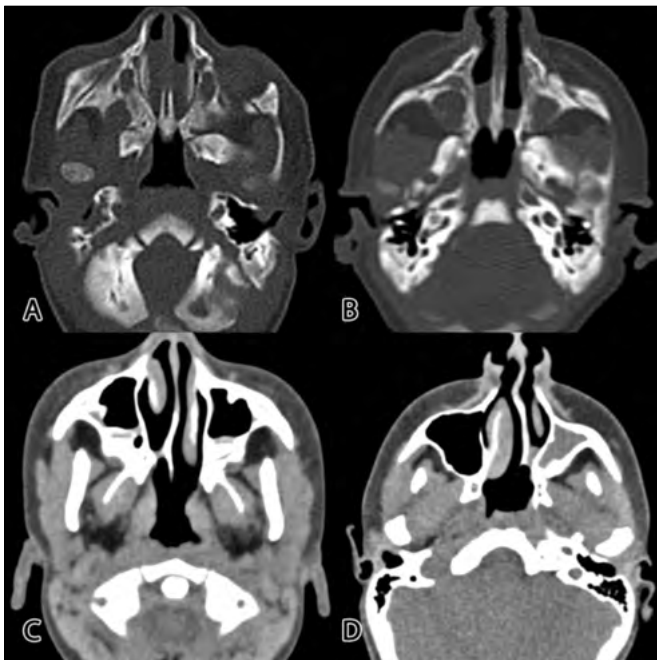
CT scan of bilateral (A-B) and unilateral choanal atresia (C-D).
